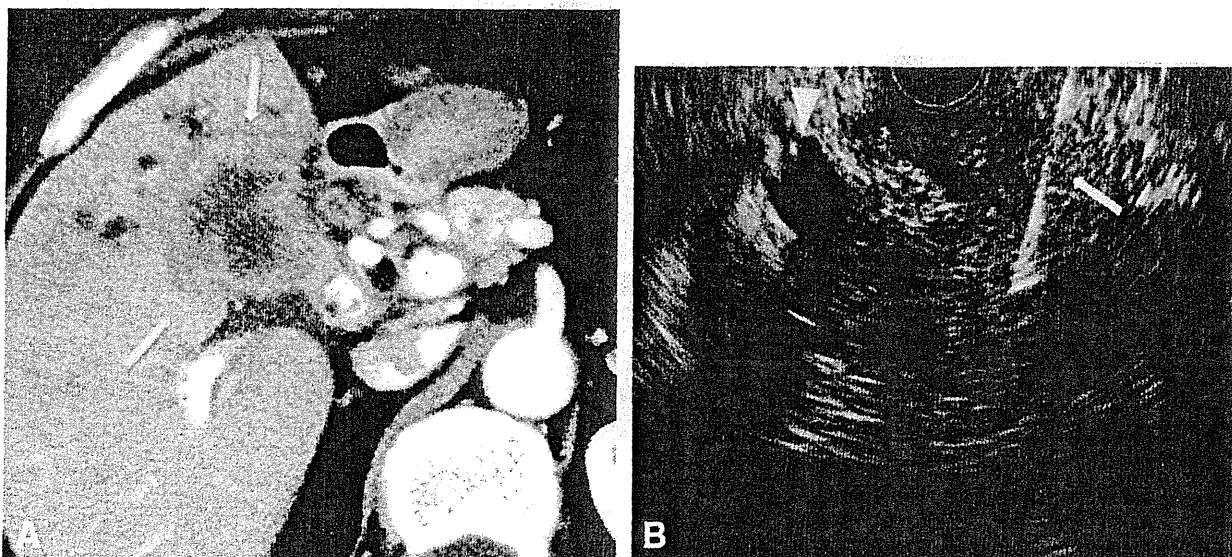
Findings of CT and EUS-guided FNA of gallbladder carcinoma from Patient 13. A, A CT image shows diffuse, irregular wall thickening and the disrupted mucosal line of the gallbladder (*arrow*). B, EUS-guided FNA for a gallbladder mass lesion (*arrow*, FNA needle inside the lesion; *arrowhead*, the gallbladder lumen).
